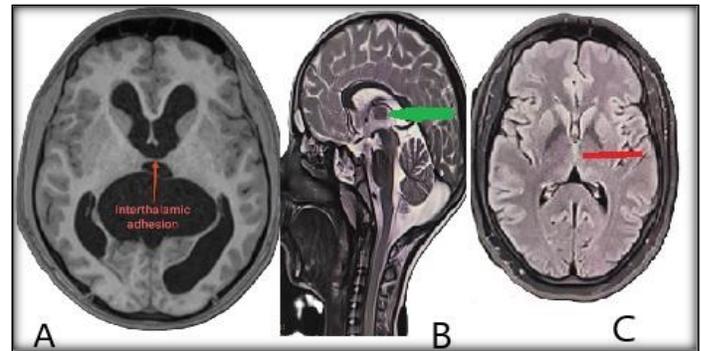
MRI of the Brain showing Interthalamic adhesion in a) the Coronal plane (red arrow), b) Sagittal plane (green arrow), and c) Axial plane (green arrow)
